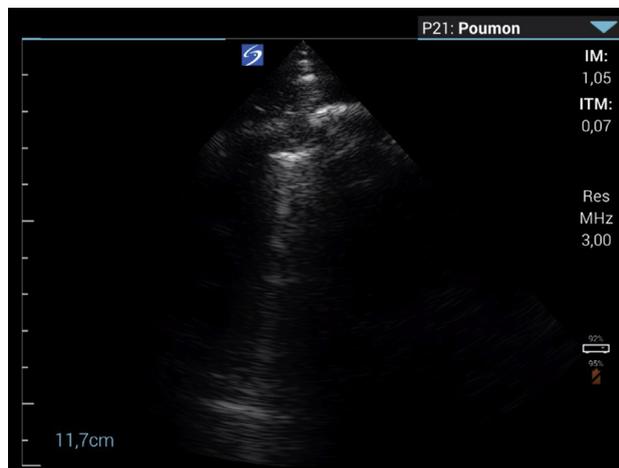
Lung ultrasound on the evening of Day 7.
